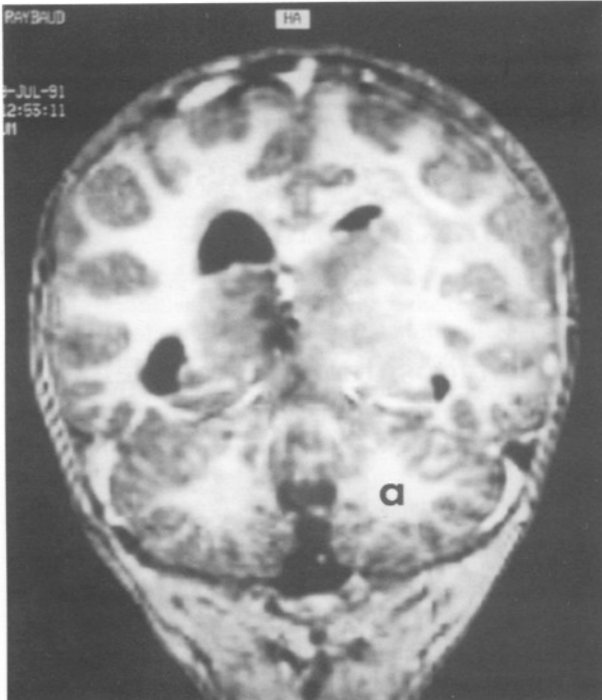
Contrast enhanced T1-weighted coronal (a) and sagittal (b) MRI scans show a poorly demarcated, isointense left thalamic tumor.
